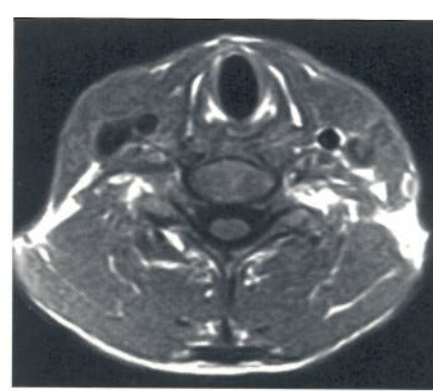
Spin Echo T1-weighted Axial Cervical Spine.
